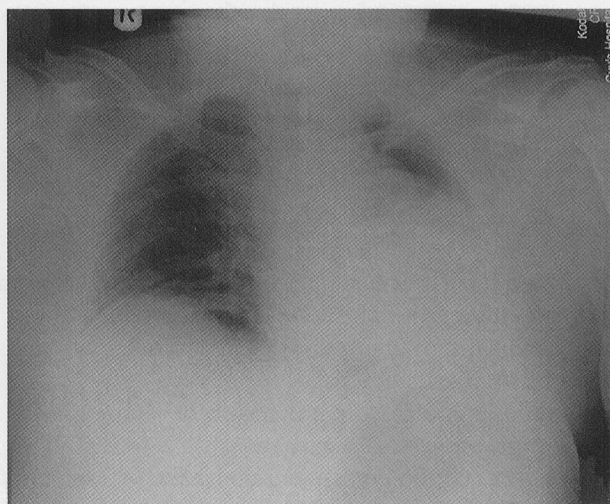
AP chest X-ray showing abnormal (?) cardiac shadow over left hemithorax.
